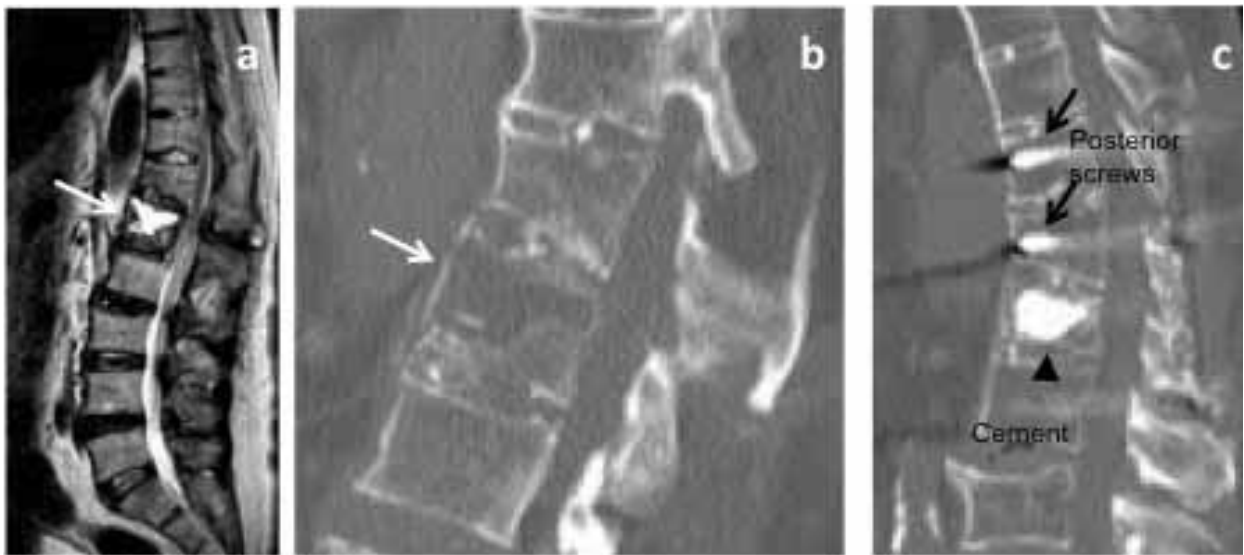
Vertebroplasty. A 60-year-old patient presented with pain and spasm and a cervical spinal injury with pseudarthrosis (white arrows) at T12/L1 that was demonstrated on (a) sagittal T2-weighted MRI and (b) CT scan. (c) Sagittal CT post anterior cement augmentation (black arrowhead) and posterior screw stabilization (black arrows) are shown.
